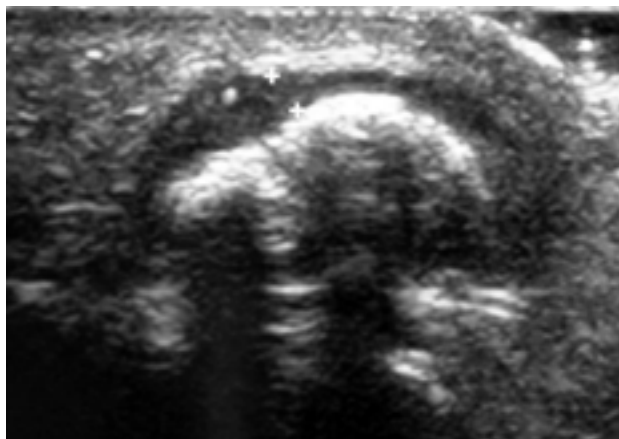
High resolution ultrasound in transversal view: calcified lesion surrounded by a thin hypoechoic cap
